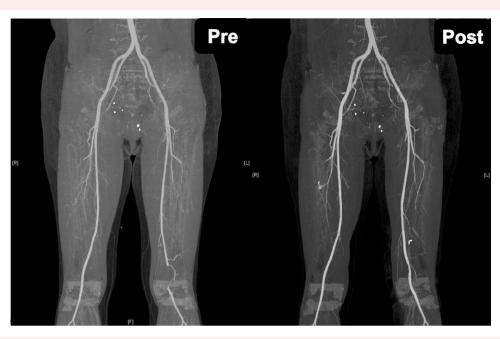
Computed tomography angiographic multiplane image reconstruction pre- and post-operation in Case 1.
